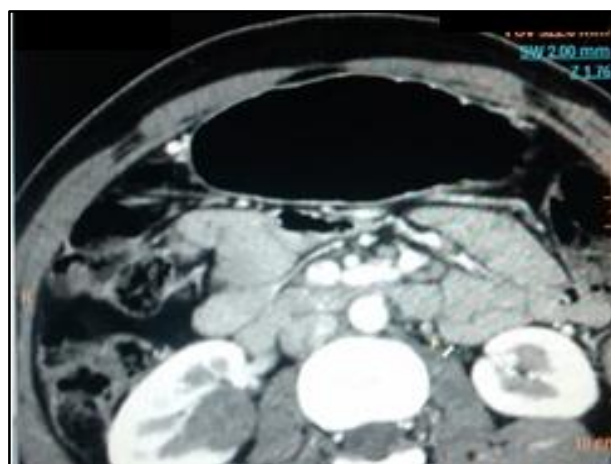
CT appearance of Oncocytoma. CECT Axial Image showing Well-Defined Soft Tissue Density Mass in the Right Kidney
